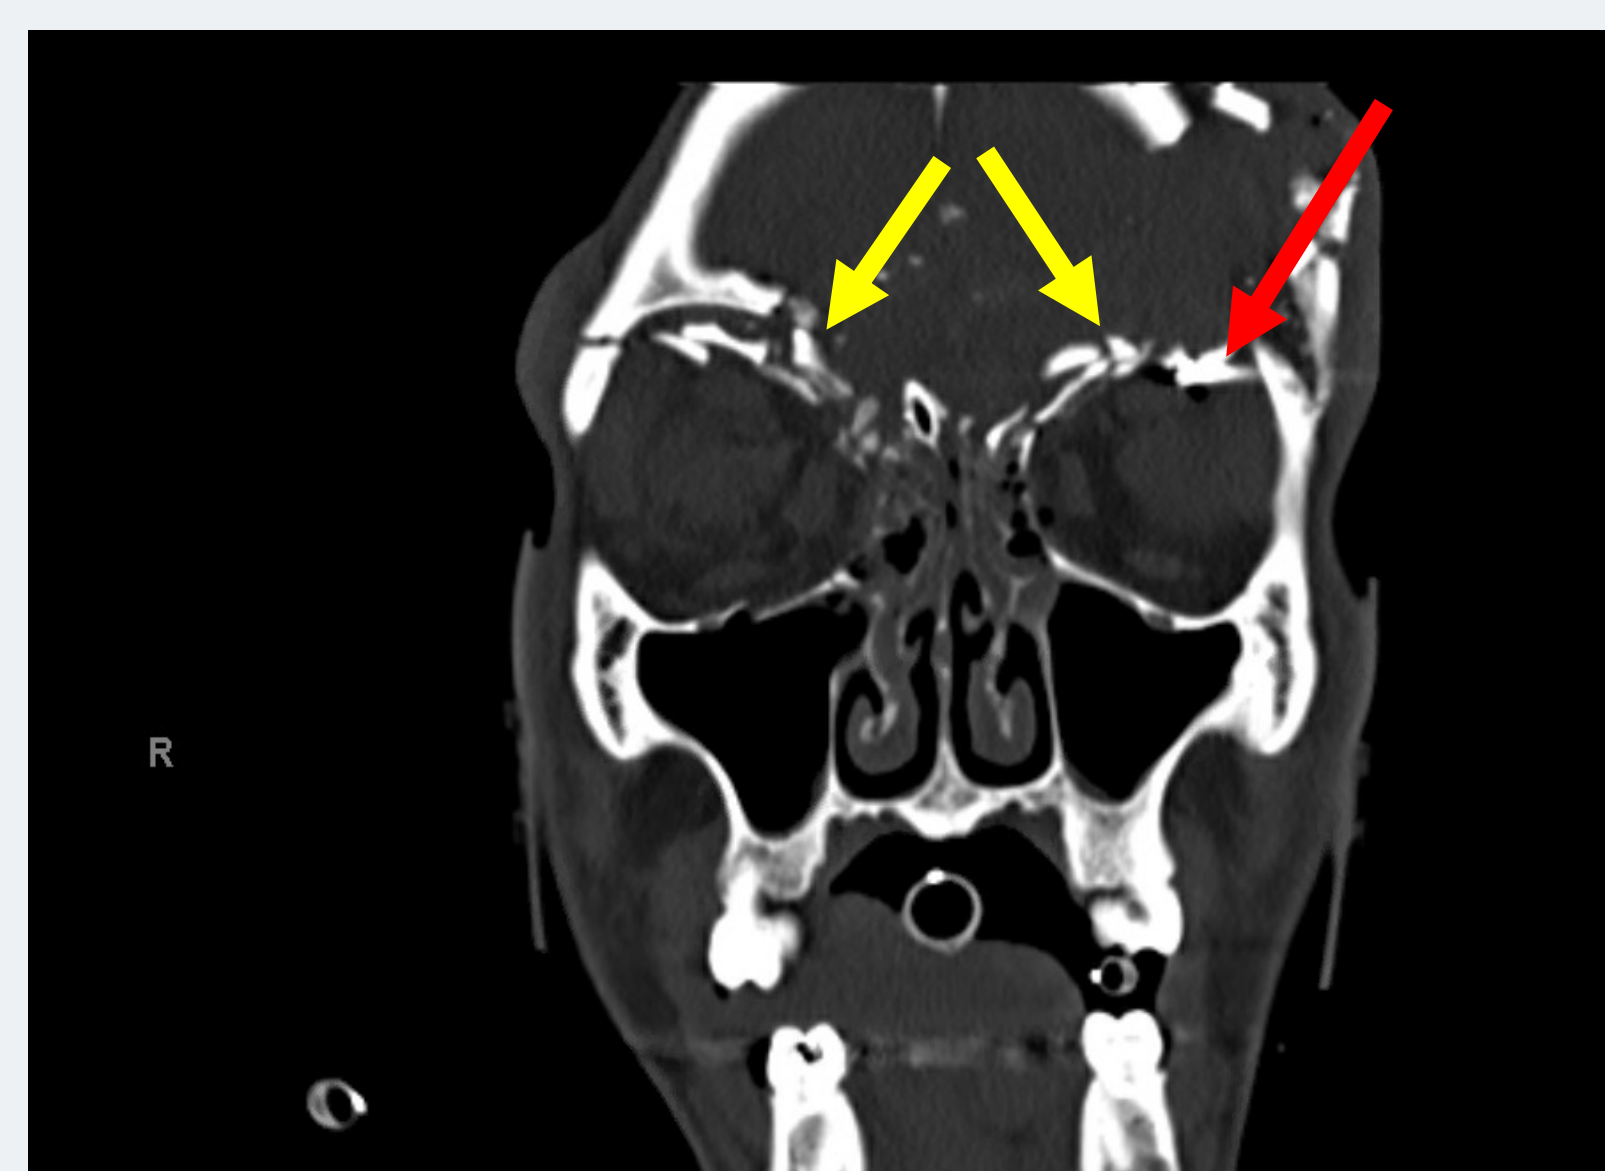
Frontal (left) and coronal (right) CT scans of the head demonstrate comminuted fractures (yellow arrows) through the anterior skull base and front bones extending to the orbit due to a penetrating bullet injury (red arrows).
